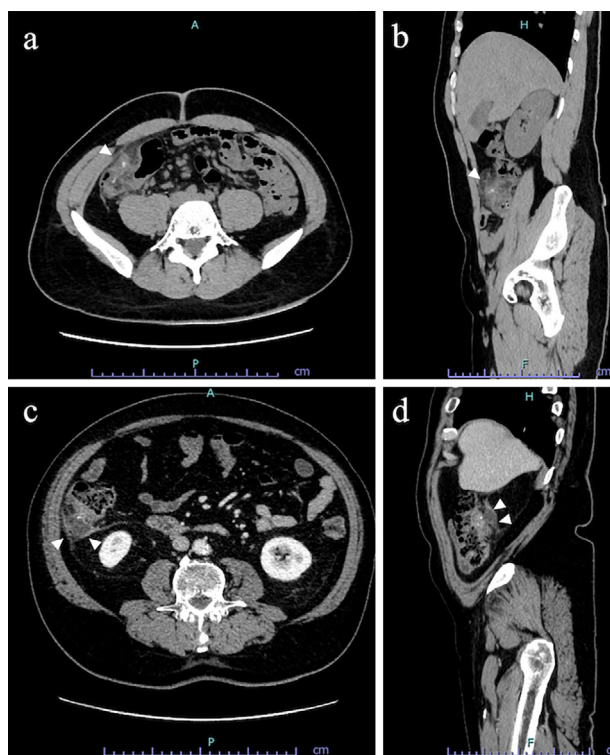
Computed tomography images for stage 1a (a: horizontal view, b: sagittal view) and suspected 1b (c: horizontal view, d: sagittal view) according to the modified Hinchey classification for the severity of acute diverticulitis. In the upper row, bowel wall thickening and pericolic inflammatory reactions with fat stranding pericolic fat (arrowheads, a, b) are observed, indicating stage 1a. In contrast, in the lower row, a small amount of fluid accumulation is noted around the diverticulum, which is confirmed to not be an abscess (arrowheads, c, d), without free air, indicating stage 1b.
